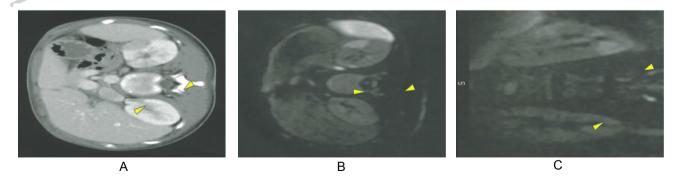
A) Enhanced CT image showing a low-density abnormal area in the left kidney (arrows). B,C) Abdominal MRI-DWI reveals wedge-like shaped high signal intensities in the left kidney (arrows).
